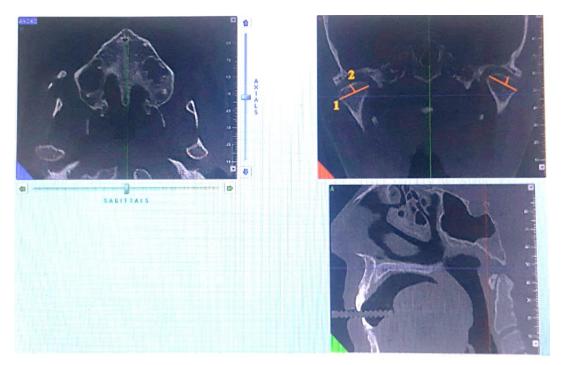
MidwiPth Bilateral maximum diameter of the condylar head seen on a coronal CBCT section.
